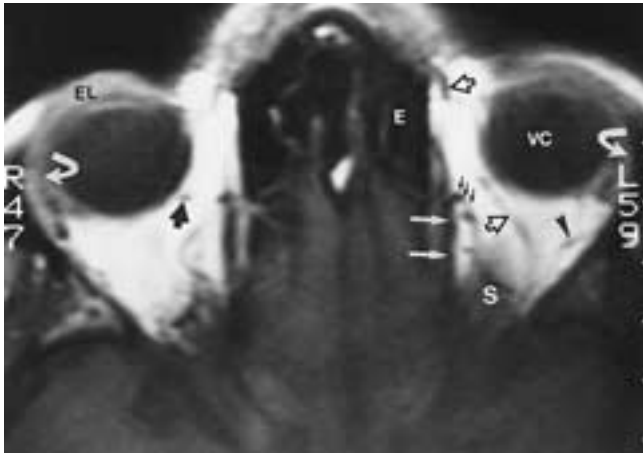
Normal MR imaging anatomy. T1-weighted MR image obtained 6 mm superior to the view in Figure 9-17 shows the superior rectus muscle (S); lacrimal vein (arrowhead); lacrimal glands (curved arrows); superior ophthalmic vein (hollow arrows); medial ophthalmic vein (three small arrows); superior oblique muscle (white arrows); presumed vorticosus vein (solid black arrow); eyelid (EL); and vitreous chamber (VC).
